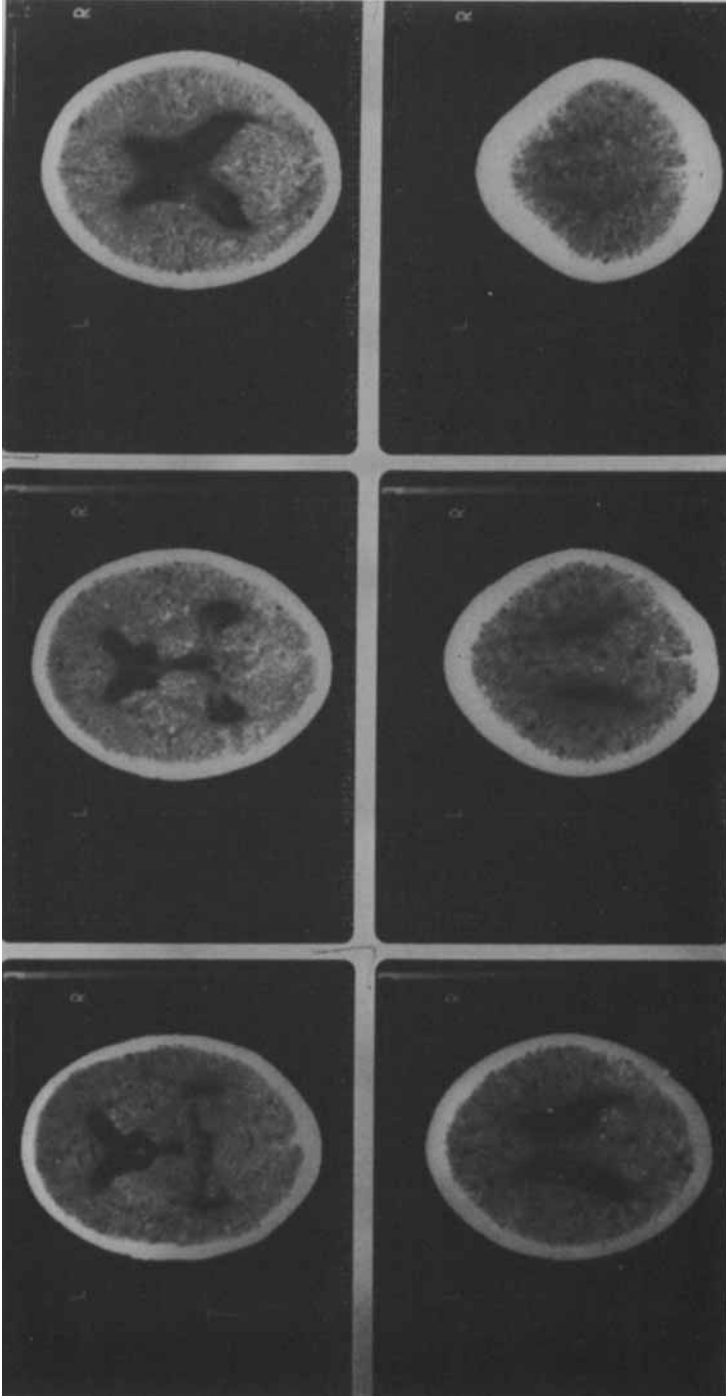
CT scan after treatment. Significant increase in the size of the ventricles is observed.
